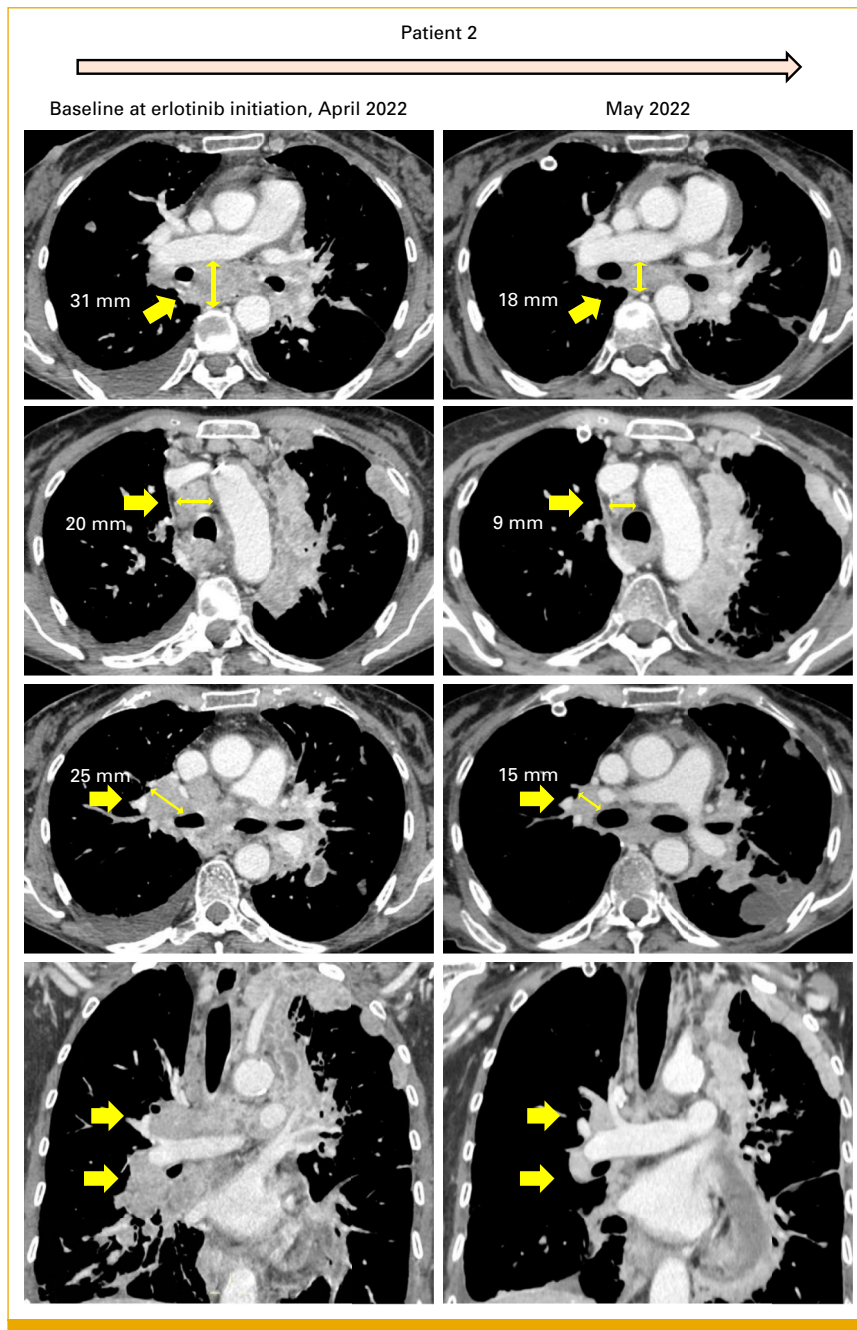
Radiographic assessment of erlotinib activity in patient 2. Computed tomography scans showing the tumor response to erlotinib in patient 2, with documented shrinkage of measurable disease in right hilar, subcarinal, and right upper paratracheal lymph node metastases.
